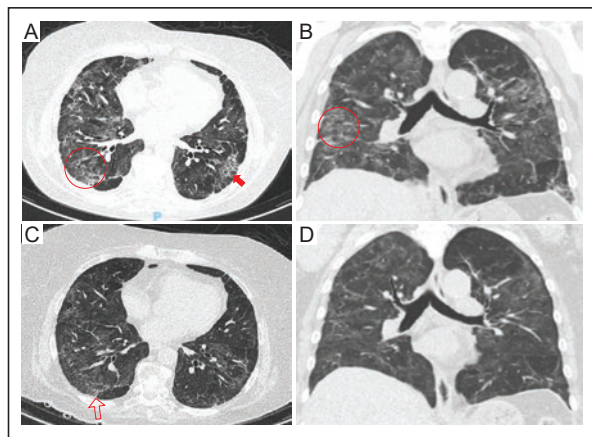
Chest CT of a 68-year-old female diagnosed with Long COVID. A: coronal and B: axial baseline images showing septal thickening and multiple areas of ground-glass opacity (circle) associated with subpleural reticular bands (solid arrow). C: coronal and D: axial follow-up images, obtained 14 months after the initial infection, show decreased density and extension of the ground-glass opacity, but persistence of interstitial centrilobular thickening and subpleural reticular opacities (open arrow).
